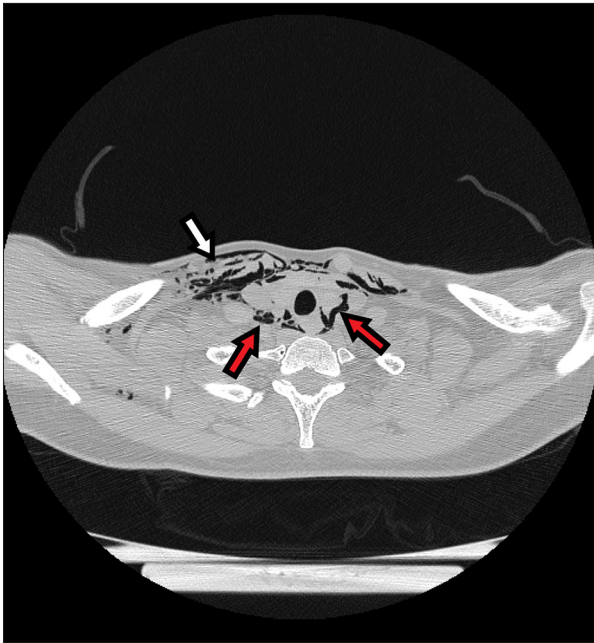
Computed tomographic axial view of the emphysema in the chest wall (white arrows) and in the mediastinum, outlining the vessels and thyroid (red arrows).
